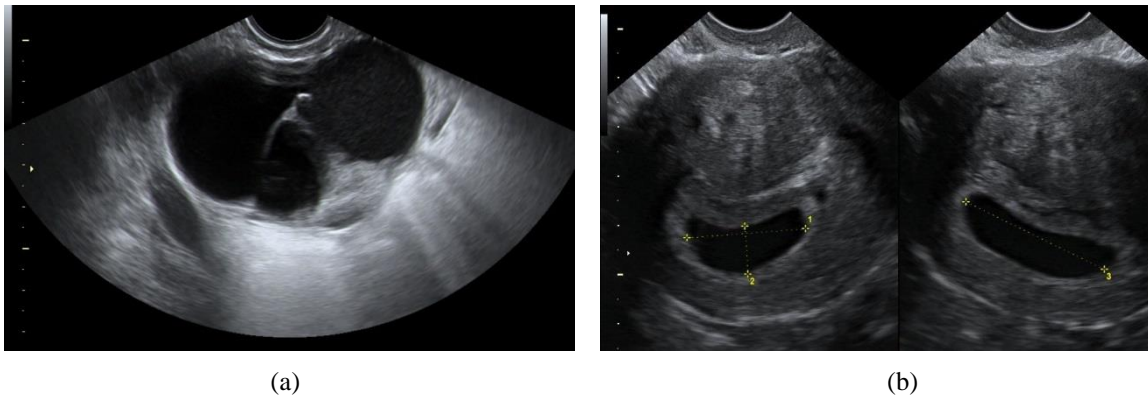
2: Examples of US scan images (a) Ultrasound image of ovarian tumour (b) Ultrasound image of Gestational sac in two different planes
